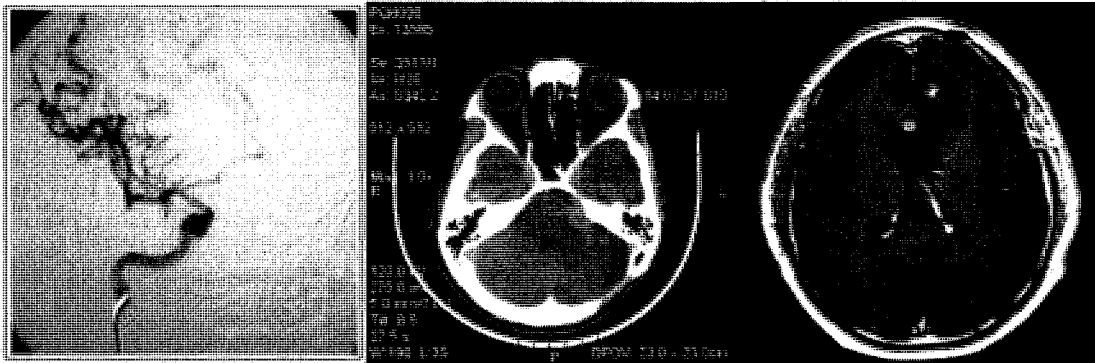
(left to right) DSA image of AVM; CT axial image of brain; and MR axial image of brain.
